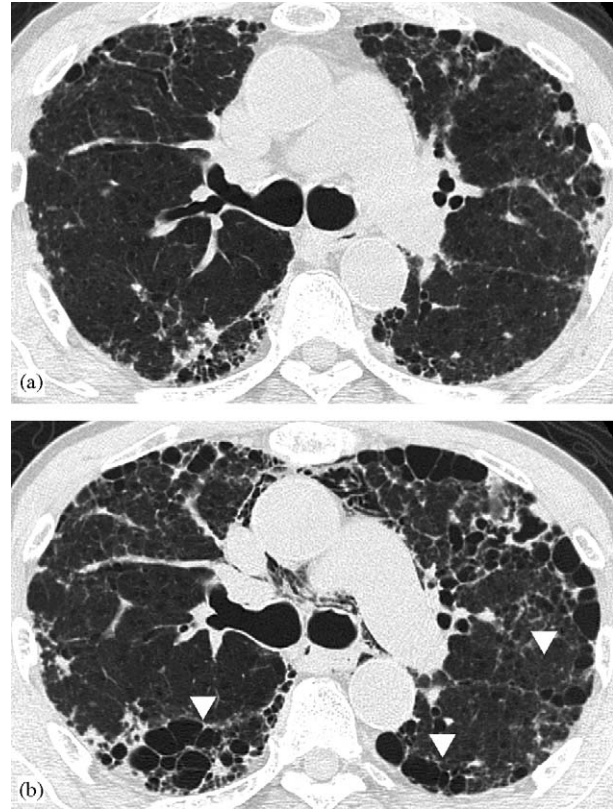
Transverse thin-section CT scans in 72-year-old man with idiopathic pulmonary fibrosis without therapy. The extent of honeycombing (white arrowhead) has been increased at the detection of pneumomediastinum (b) as compared with before CT scan (a).
